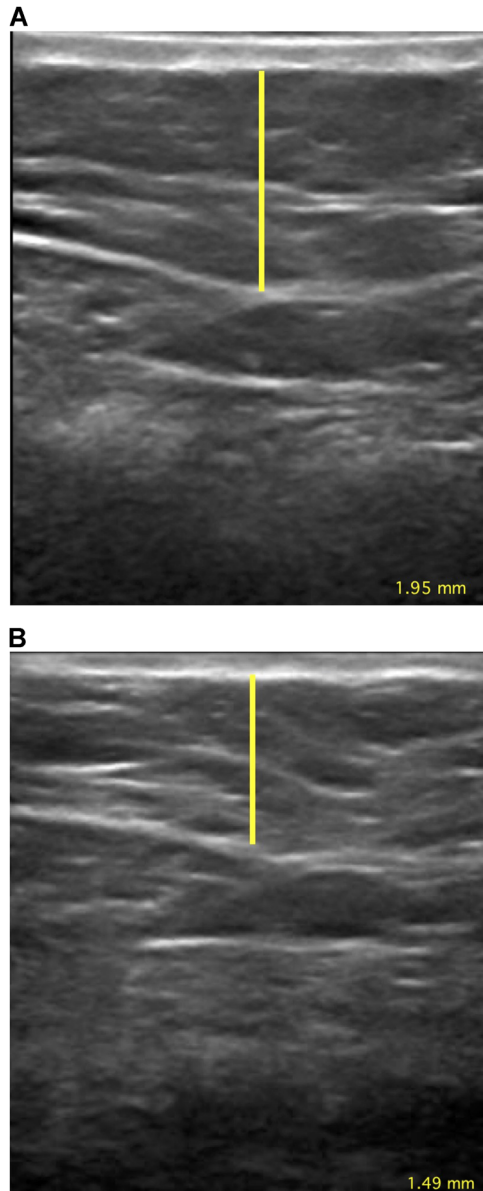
Ultrasonography of representative fat thickness assessment. Fat thickness of baseline (A) and 12 weeks after treatment (B) shows a 0.46 mm reduction of the fat layer and increased fibrous septa.
